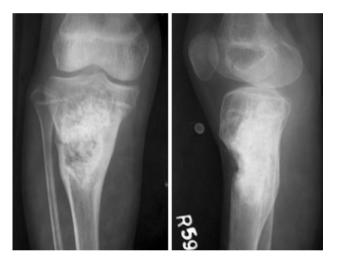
Follow-up radiographs at 6 months after surgery showing the cyst in healing phase
